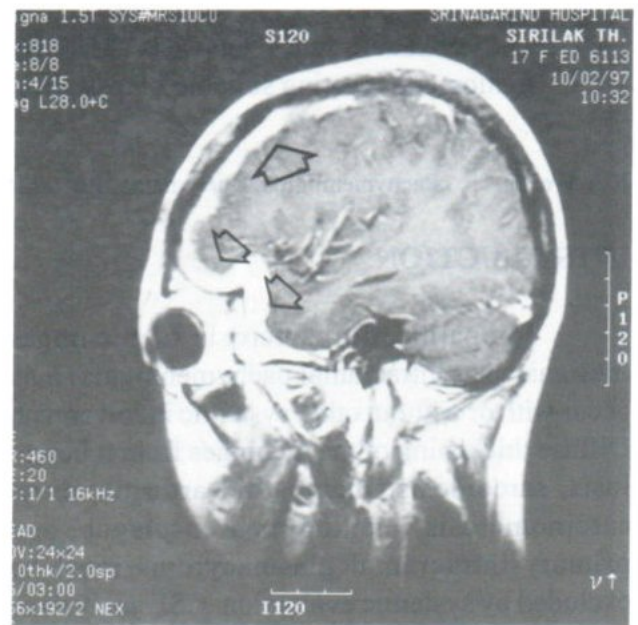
MR imaging T1W (TR 600 ms, TE 20 ms) after Gd-DTPA, sagittal plane showing diffuse thickening of inferior frontal dura and cavernous sinus (arrows).
